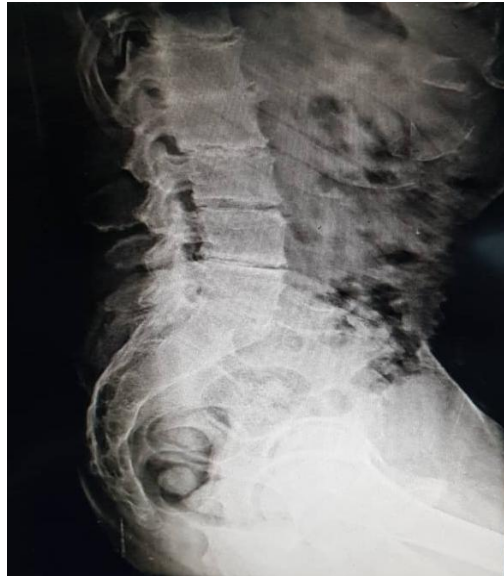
Lateral radiograph of the spine
